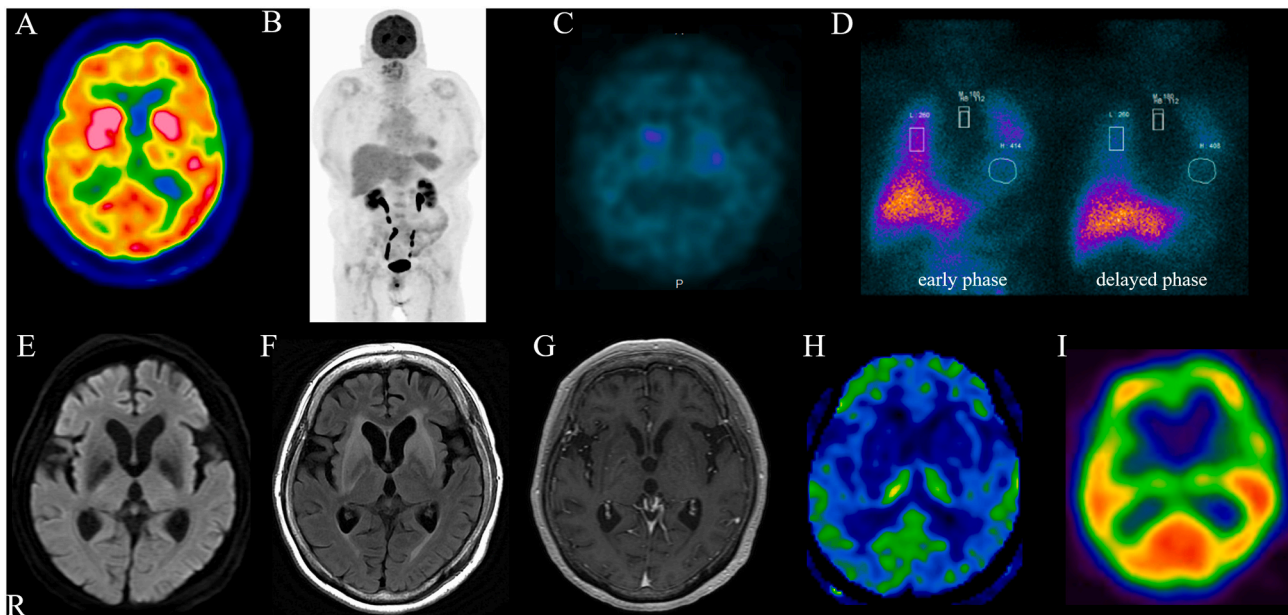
Imaging findings in our patient with anti-recoverin antibodies. (A–D). (A, B) ^{18}F -fluorodeoxyglucose (^{18}F -FDG)-positron emission tomography (PET)-CT showing accumulation of ^{18}F -FDG in bilateral basal ganglia lesions, with no accumulation in the trunk on day 5. (C) Dopamine transporter (DAT) single-photon emission computed tomography (SPECT) revealing reduced radiotracer uptake in the basal ganglia on day 38. (D) ^{123}I -metaiodobenzylguanidine myocardial scintigraphy (MIBG) showing no reduction of myocardial uptake (early phase, 2.33; delayed phase, 2.32; normal range, >2.2 , washout rate of 24.8%, normal range $\leq 30\%$, based on facility reference) on day 41. (E) DWI, (F) FLAIR, and (G) contrast-enhanced T1-WI showing edema improvement in bilateral basal ganglia lesions without contrast-enhancement on day 86. (H) Arterial spin labeling (ASL)-MRI on day 86 and (I) N-isopropyl-p- ^{123}I -iodoamphetamine (^{123}I -IMP)-SPECT for qualitative surface views on day 107 showing no bilateral basal ganglia hyper-perfusion. Abbreviations: ASL: arterial spin labeling, CT: Computed tomography, DAT: Dopamine transporter, DWI: diffusion-weighted imaging, ^{18}F -FDG: ^{18}F -fluorodeoxyglucose, FLAIR: Fluid-attenuated inversion recovery imaging, MIBG: ^{123}I -metaiodobenzylguanidine, MRI: Magnetic resonance imaging, ^{123}I -IMP: N-isopropyl-p- ^{123}I -iodoamphetamine, PET: Positron emission tomography, SPECT: single-photon emission computed tomography, WI: weighted image.
